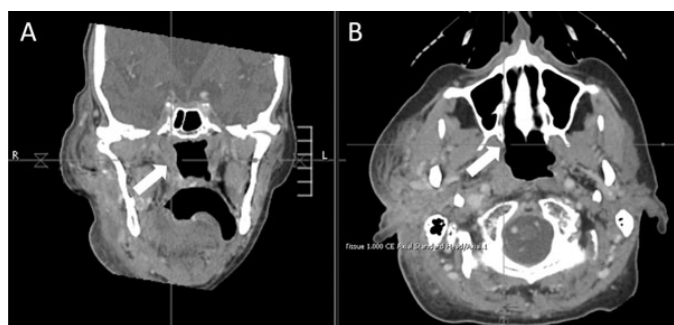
Maxillofacial computed tomography scan in coronal (A) and transverse (B) views demonstrating right parotid gland enlargement (white arrows) without fluid collection.
